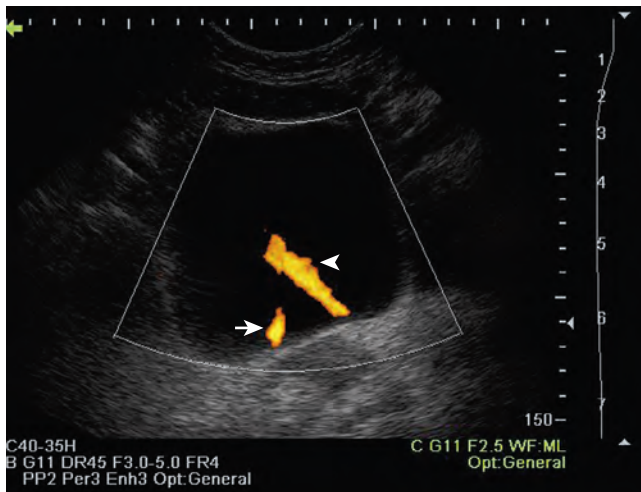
In this transverse view of the bladder, urine “jets” emerging from the left (arrow) and right (arrowhead) ureteral orifices are demonstrated by power Doppler.
